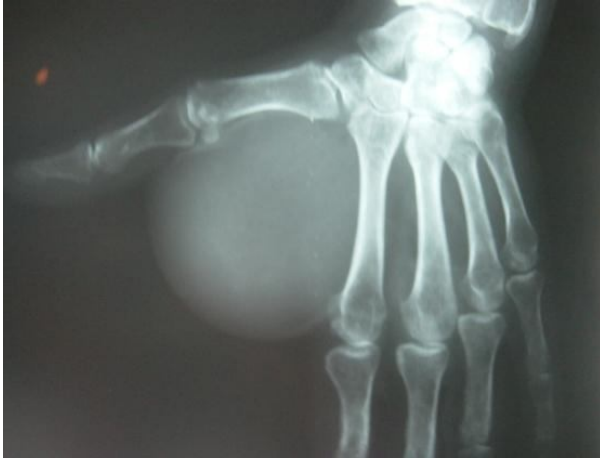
X-ray : round opacity of the first commissure without bone defect
